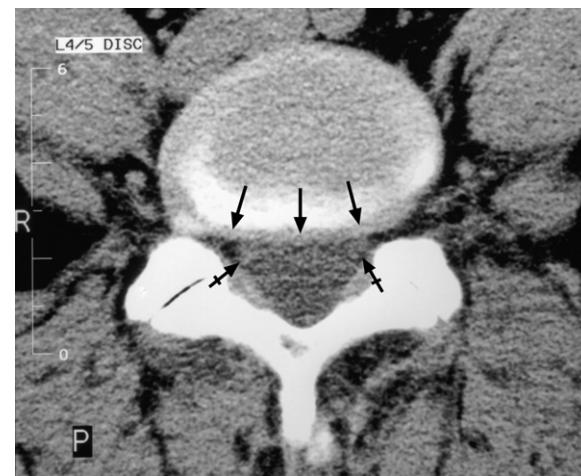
CT axial image through the L4–5 intervertebral disc level. Note the ‘mild concentric disc bulge’ (black arrows) that, in fact, abuts, to some degree, the pain sensitive anterior surface of the dural tube and the left and right nerve roots (black tailed arrows).
